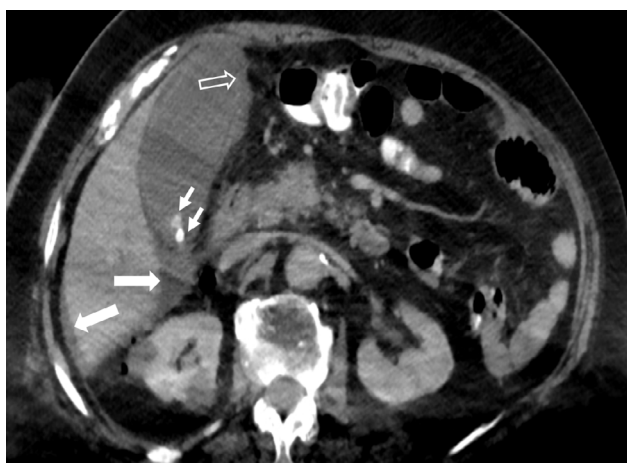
Calculus acute cholecystitis. An 84-year-old male patient. He was admitted to the emergency department due to chills, shivering, and abdominal pain that had started 2 days ago. Contrast-enhanced computed tomography shows hydrops in the gallbladder. Millimetric hyperdense structures representing stones (small arrows) are seen at the level of the gallbladder neck. Irregularities in the wall, especially at the level of the fundus of the gallbladder, are striking (hollow arrow). A small amount of fluid (large arrows) is noted in the pericholecystic and perihepatic areas. Percutaneous gallbladder drainage was performed. The patient, who developed low saturation during the follow-up, was admitted to the intensive care unit. She was discharged after staying in the intensive care unit for 4 days
